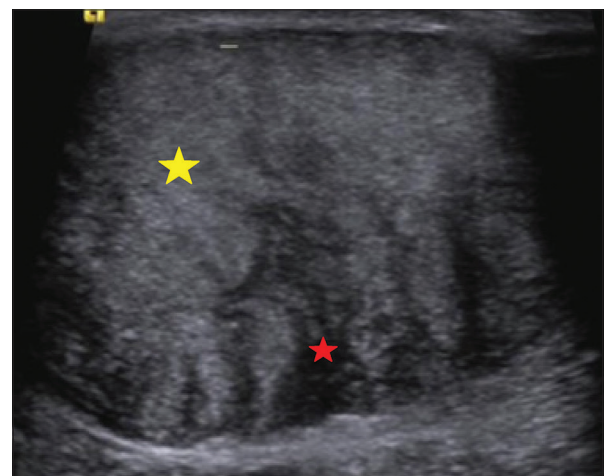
Axial ultrasound image of Achilles tendon demonstrates a fusiform enlargement of Achilles tendon (yellow asterisk). A focal hypoechoic area is demonstrated on the anterior aspect (red asterisk) (corresponding to the T1 isointense lesion of magnetic resonance imaging in Figure 2a).
